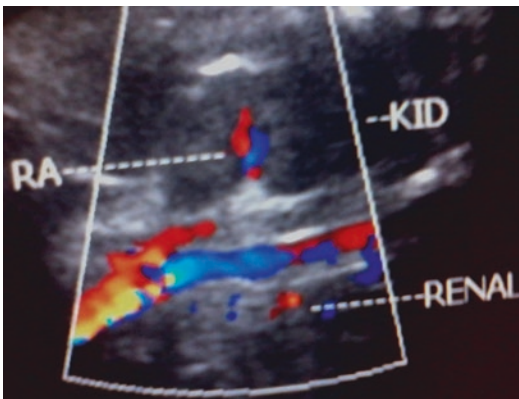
Visualisation of both renal arteries in power Doppler
